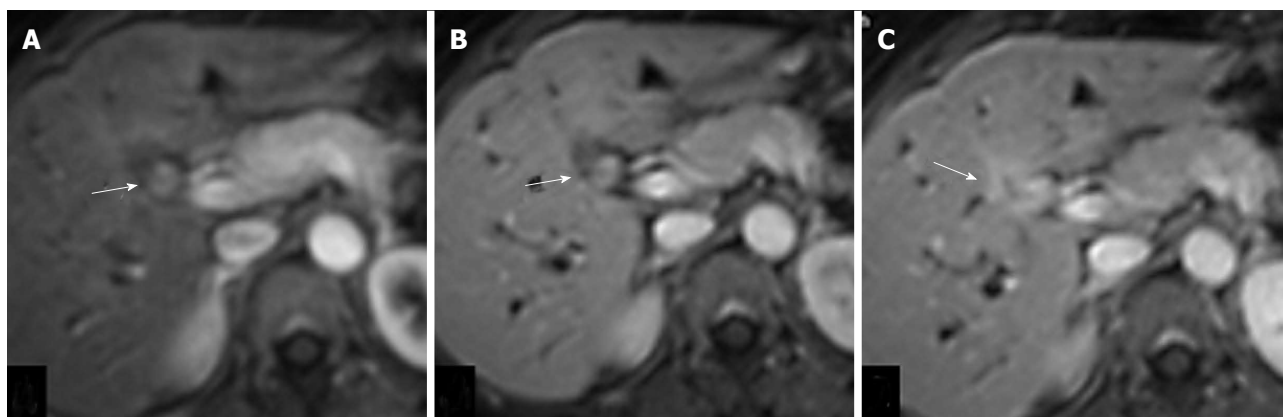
Axial contrast enhanced T1-weighted magnetic resonance images in arterial (A), venous (B) and delayed (C) phases of periductal infiltrating variety of hilar cholangiocarcinoma showing mildly enhancing thick walled proximal hepatic duct in arterial phase (arrow) with increasing contrast enhancement in venous and delayed phases.
